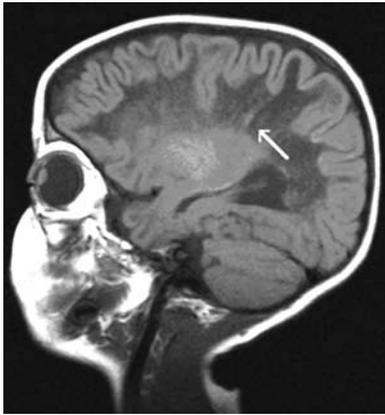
Sagittal T1-weighted image showing extensive white matter low signals, with evidence of white matter stripes.
